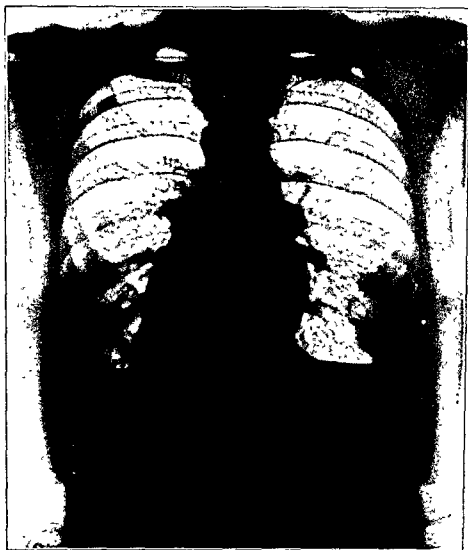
A posterior-anterior x-ray of the thorax of an adult female complaining of cough, expectoration and hemoptysis, which disclosed no evidence of clinical pulmonary disease. An oblique position, Fig. 17, however, accounted for the symptoms.
